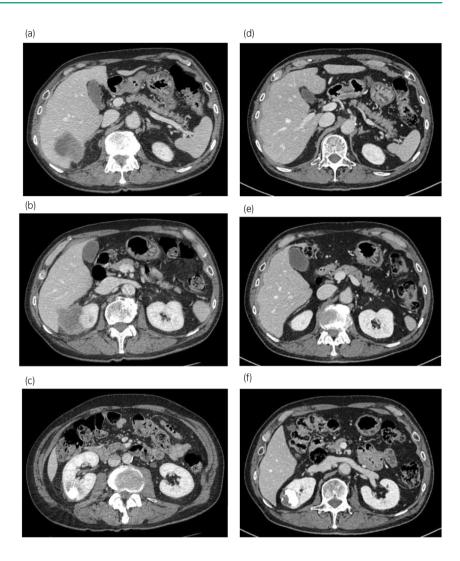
Contrast-enhanced CT showed a hypodense mass with capsular enhancement effect extending from the upper pole of the right kidney to the right lobe of the liver (a–c). A CT scan performed 10 months earlier had revealed the presence of a renal cyst with internal calcification at the upper pole, but not a right renal mass (d–f).
